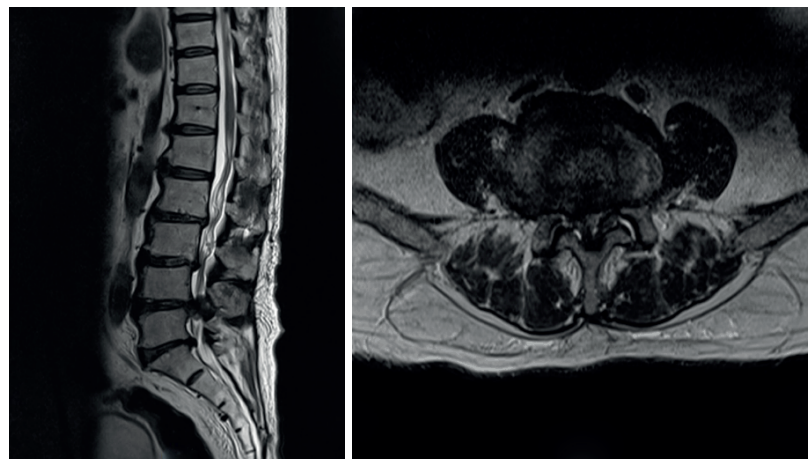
Preoperative sagittal and axial lumbar magnetic resonance images show severe central stenosis compressing cauda equina at L4-5 level.
